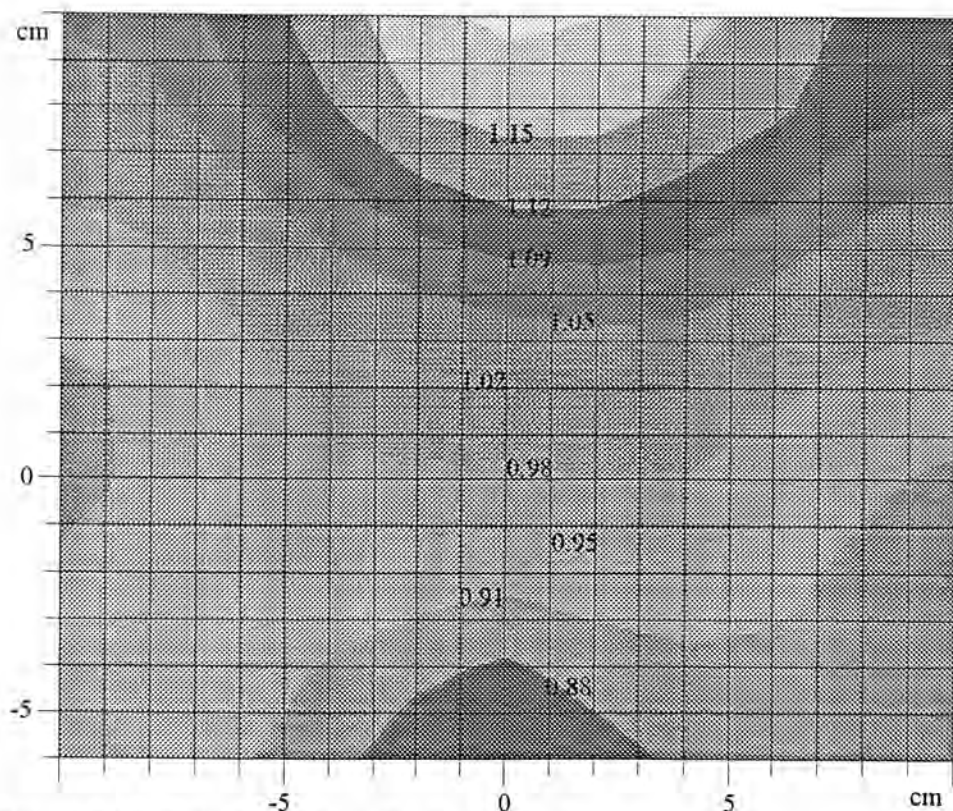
Calculated dose distribution in the representative section (no. 14) of the chest area for the Siemens Somatom Plus CT scanner.
